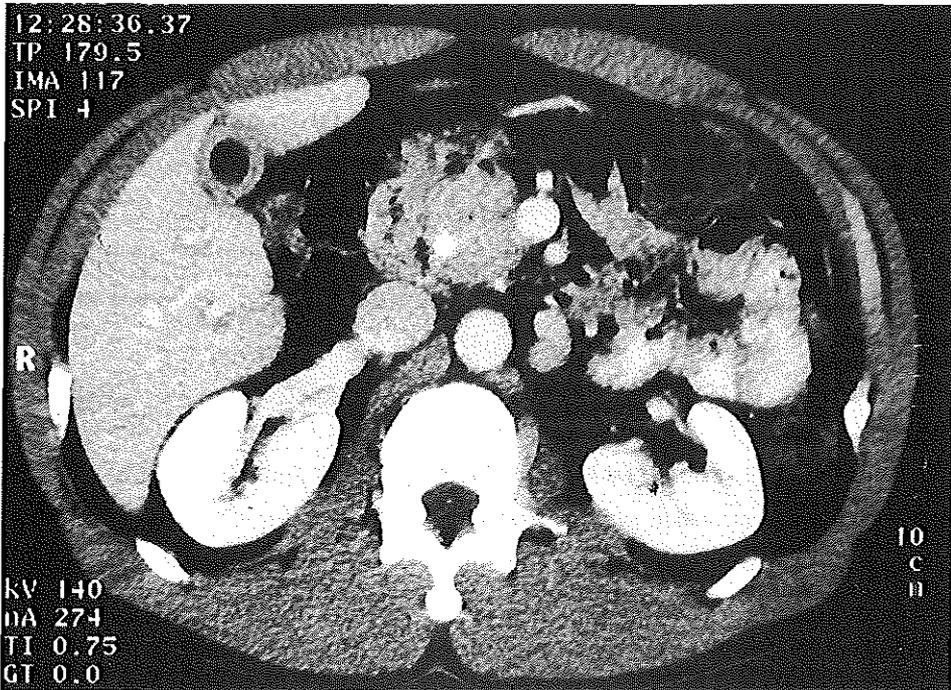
Computed tomography scan of patient no 1 showing enlargement of the pancreatic head region. A biliary endoprosthesis is located in the centre.
